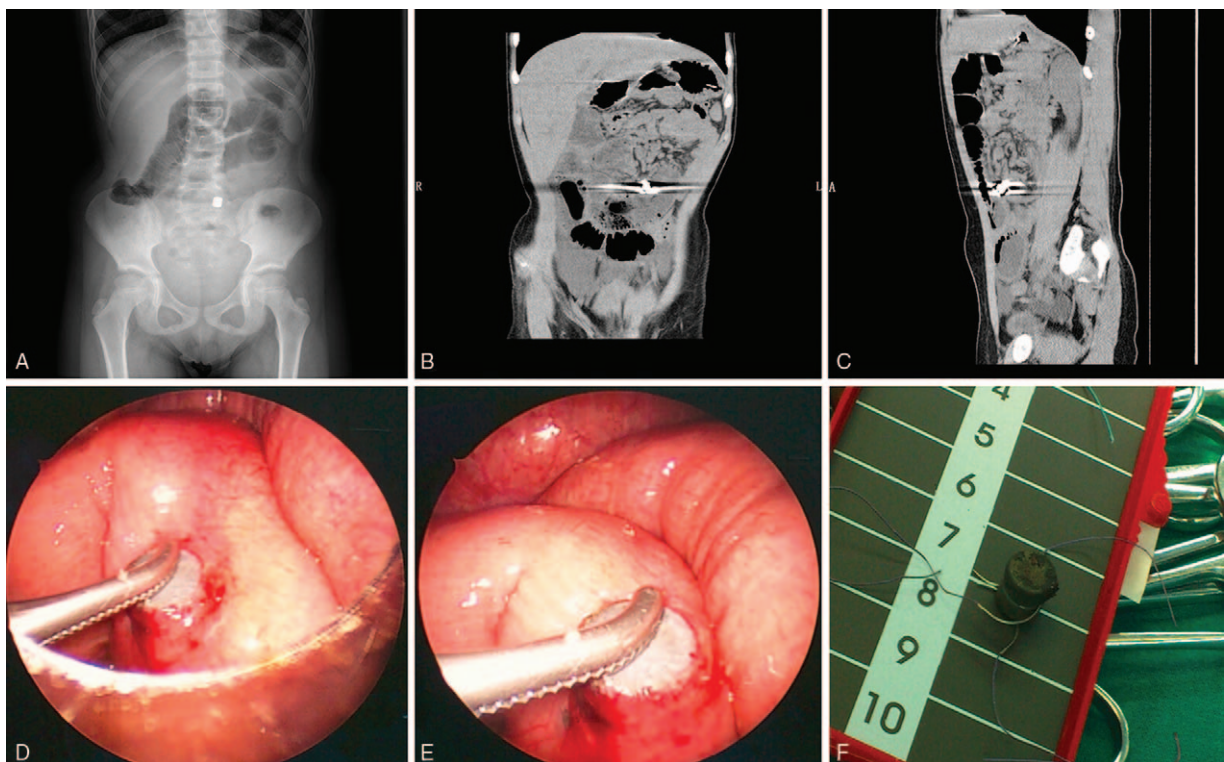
(NO7) A 8-year-old boy suffered from abdominal pain for 3 days. Plain abdominal x-ray images showed gastrointestinal perforation and a FB of high density in the abdomen. FB=foreign body.
